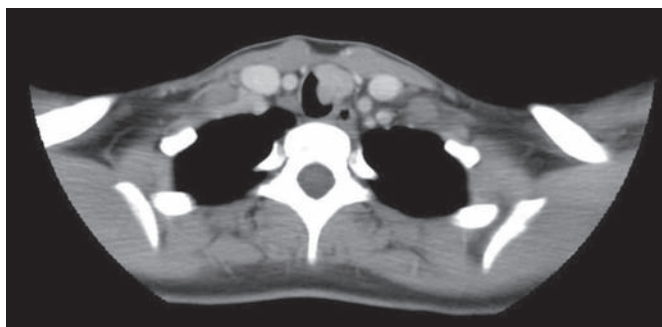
CT of the thorax showing a moderately enhancing soft tissue lesion involving the left anterolateral wall of the trachea at the T3 vertebral level causing luminal narrowing.
